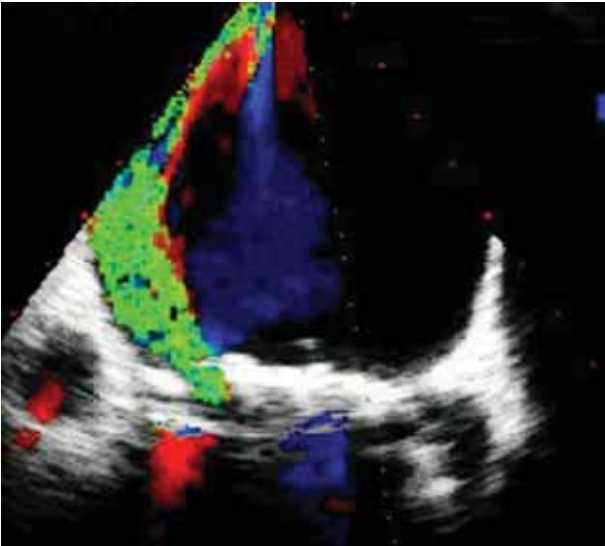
Transesophageal echocardiography documented a posterior mitral annulus leakage with a major regurgitant jet.
